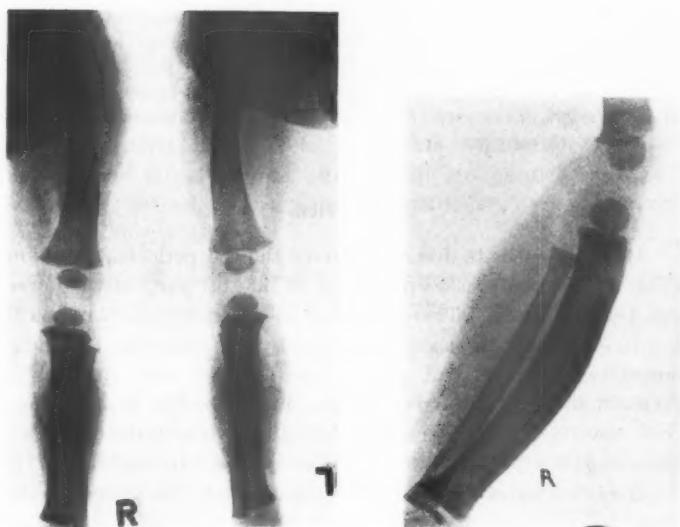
Case III. Roentgenogram on 1/10/1947, 3 months after the onset of the disease. The periosteal thickening along the tubular bones is beginning to assume an osseous structure. Here too the tibia is curved forward.
